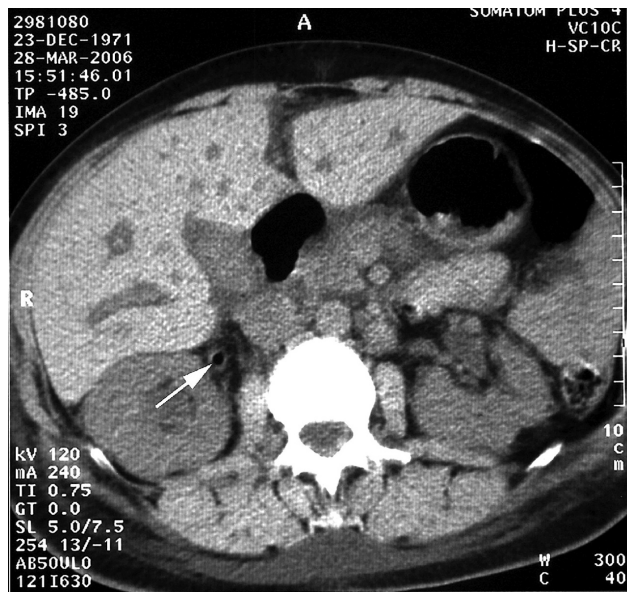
Emphysematous pyelonephritis: computed tomography (CT) scan demonstrating gas in the right ureter (indicated by arrow) and a moderate hydronephrosis in a 34-year-old woman with type 1 diabetes. The responsible organism was *E. coli*. She responded to antibiotics and drainage by nephrostomy, followed by ureteroscopy during which obstructing necrotic slough was removed. Source: Clark T, et al. A case of emphysematous pyelonephritis. *J R Soc Med* 2009; 102:75–77. Copyright © 2009 SAGE Publications.
